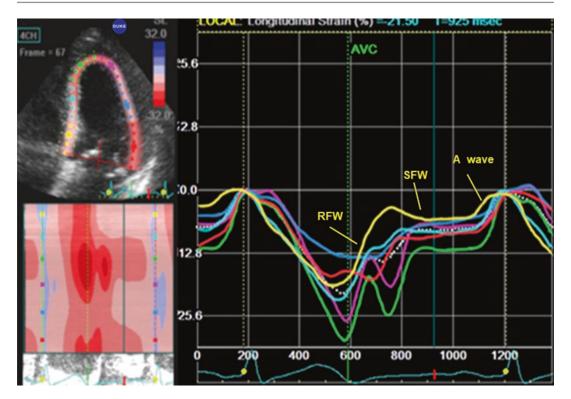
Apical four-chamber view with strains from a normal individual. All the strain curves are negative and have their nadir at, or about, aortic valve closure in this normal tracing. GLS (dashed white line) is about -21%
